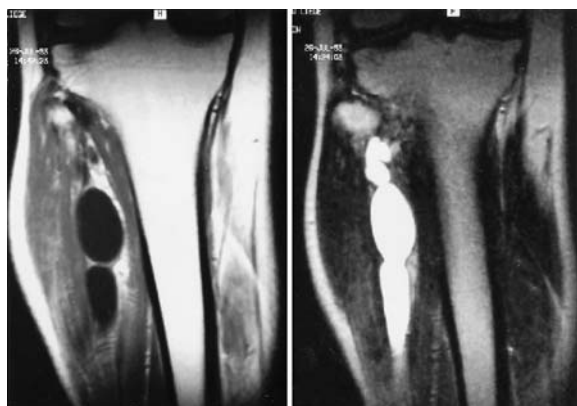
Preoperative magnetic resonance images, coronal view. A T_1 -weighted image obtained after injection of gadolinium (left) and a T_2 -weighted image (right) demonstrating a lobulated homogeneous cyst that has attained some contact with the head of the fibula but none with the tibiofibular joint.
